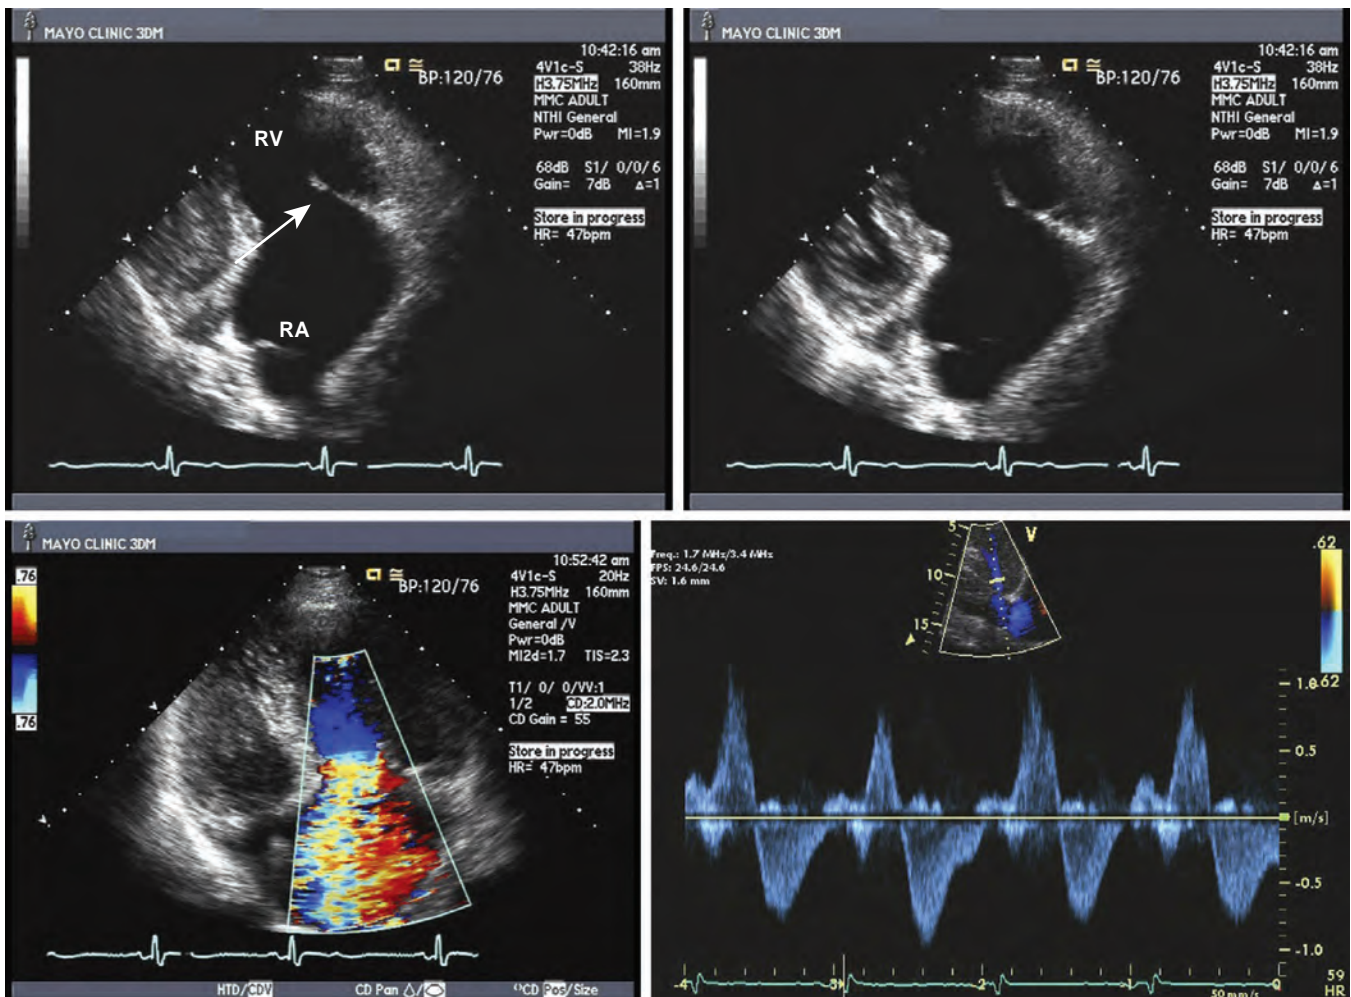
Transthoracic imaging using an apical view in a patient with carcinoid heart disease.
